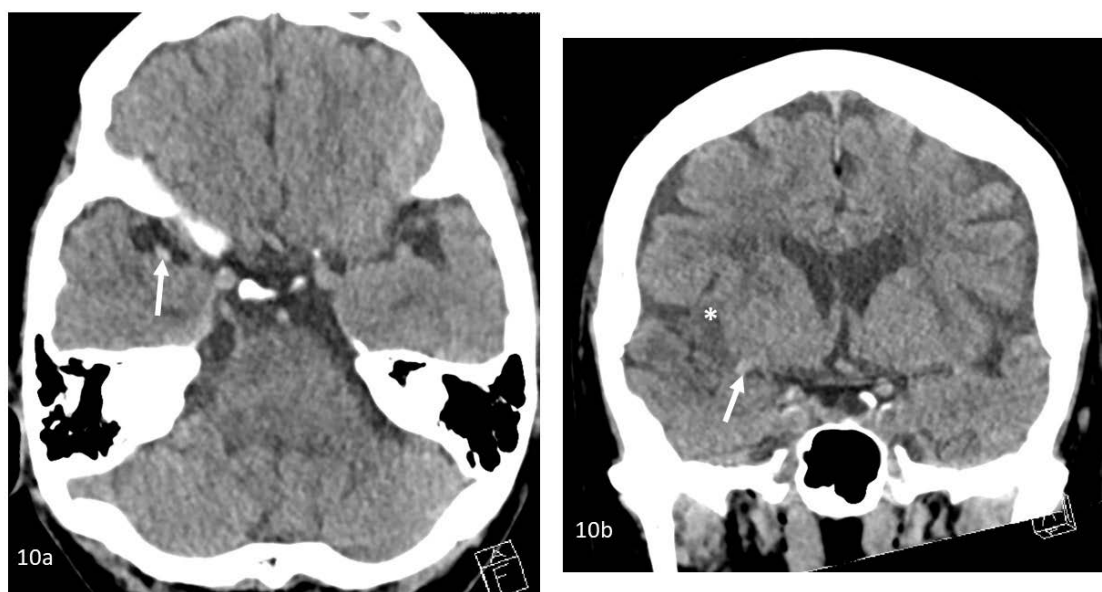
Hyperdense MCA sign and loss of insular ribbon sign. 72 year old female with acute right MCA infarct. Axial (10a) and coronal (10b) unenhanced CT brain shows a hyperdense right MCA (white arrow) which is due to the offending thromboembolus in the right MCA. There is also loss of gray-white differentiation and edema at the right insular cortex (white asterisk) which is referred as the "loss of insular ribbon sign", suggestive of an acute right MCA infarct. Toshiba Aquilion Prime, Slice width 3.0 mm, 120 kV, 150 mAs
